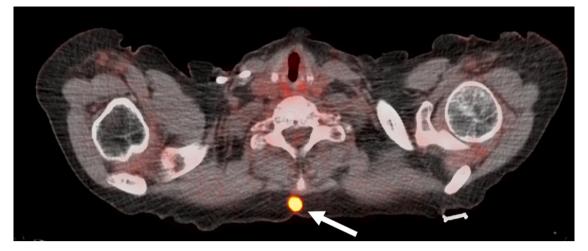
Axial fused PET/CT image of 56-year-old male showing an FDG avid nodule in the posterior chest wall subcutaneous tissue consistent with metastatic disease (arrow).
